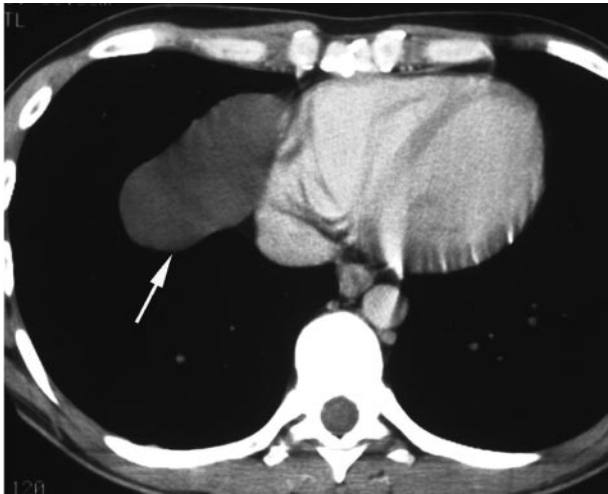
A 37-year-old man with a pericardial cyst. A contrast-enhanced CT scan shows a thin-walled water-attenuation cyst (arrow).
